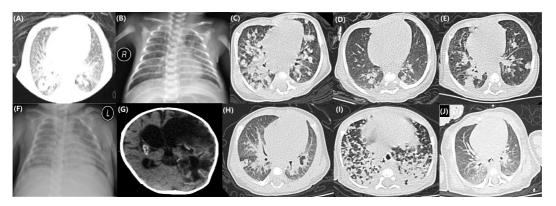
Imaging findings: (A) Chest CT scan of patient #1 exhibited multiple pulmonary nodules, bronchopneumonia and mediastinal adenopathy; (B) Chest X-ray of patient #2 exhibited extensive patchy and granular shadows in both lungs; (C) Chest CT scan of patient #3 exhibited multiple pulmonary nodules; (D) Chest CT scan of patient #5 exhibited multiple pulmonary nodules; (E) Chest CT scan of patient #6 exhibited multiple pulmonary nodules and mediastinal adenopathy; (F) Chest X-ray of patient #7 exhibited extensive patchy and granular shadows in both lungs; (G) Brain CT scan of patient #7 exhibited cerebral infarction, hydrocephalus, encephalomalacia and cerebral atrophy; (H) Chest CT scan of patient #8 exhibited multiple pulmonary nodules; (I) Chest CT scan of patient #9 exhibited multiple pulmonary nodules; (J) Chest CT scan of patient #10 exhibited multiple pulmonary nodules.
